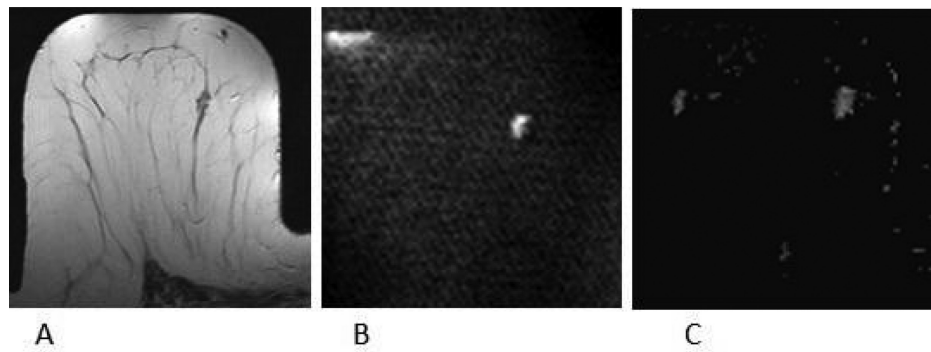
Invasive ductal carcinoma of 11 mm. An irregularly shaped mass is visible on the T2-weighted image (A). The mass is highly visible and has high DWI signal as seen on the high b value image. Malignancy score was 5-6 on qualitative assessment (B). The ADC value of the mass was measured as $0.95\text{--}1.02 \times 10^{-3} \text{ mm}^2/\text{s}$ on ADC map (C).
